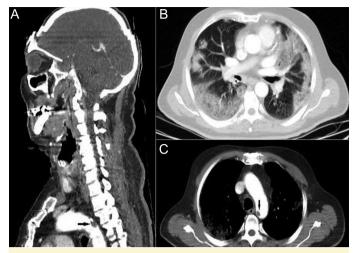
A-C. (A) Black arrow indicates thrombus attached to the aortic arch wall with its narrow base. (B) Chest computed tomography scan showing bilateral ground glass opacification with consolidation compatible with COVID-19 pneumonia. (C) Aortic thrombosis seen in the aortic arch.
